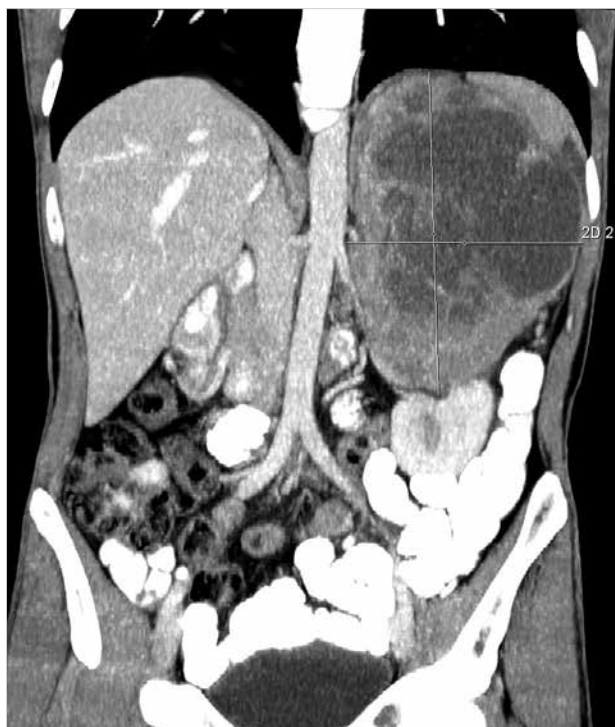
Large pheochromocytoma on computed tomography (coronal section)
